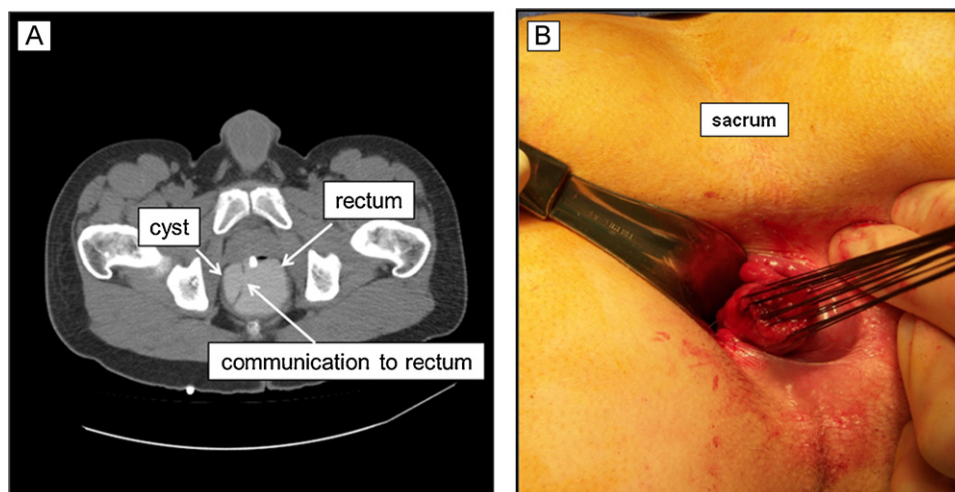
(A) Axial CT, duplication cyst on right with wide communication with rectum; (B) retractor in rectum, circumferential sutures on orifice of duplication cyst for traction.
